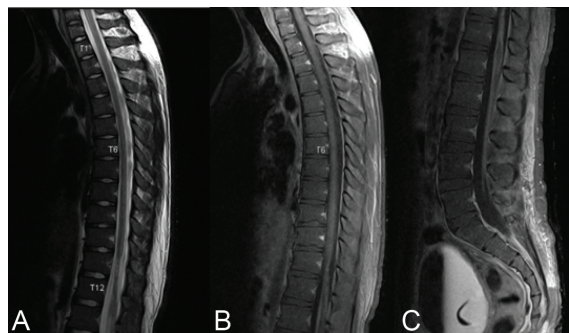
MRI of thoracolumbar spines 2 months after first imaging. A) Sagittal T2 weighted imaging, showing decreased size of the longitudinal T2 hypointense lesion and spinal cord edema with small size of the T11-T12 spinal cord. B, C) Sagittal T1 weighted postgadolinium of thoracic and lumbar levels, showing nodular enhancement of the T11-T12 spinal cord, leptomeningeal enhancement along lower thoracic cord surface, and enhancing and clumping of cauda equina nerve roots.
